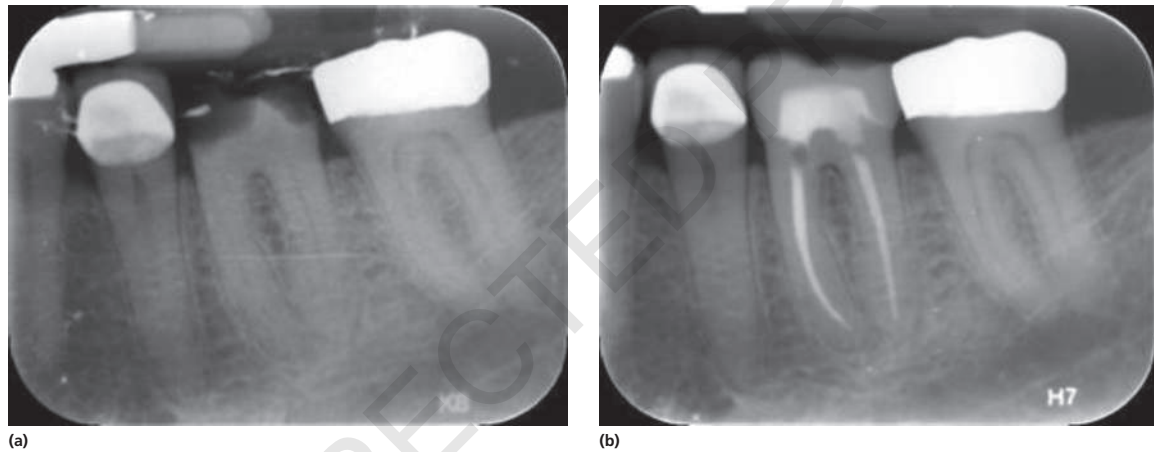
(a) Radiograph of a lower right first molar in a 71-year-old male patient. Note the large carious lesion at the distal gingival margin below the restoration with successful root canal therapy in the second molar. (b) The caries has been removed and packed with amalgam and the tooth has a second root canal treatment. This case was seen by a periodontist who told the patient that it could not be retained and a crown restored implant would be a better treatment.
